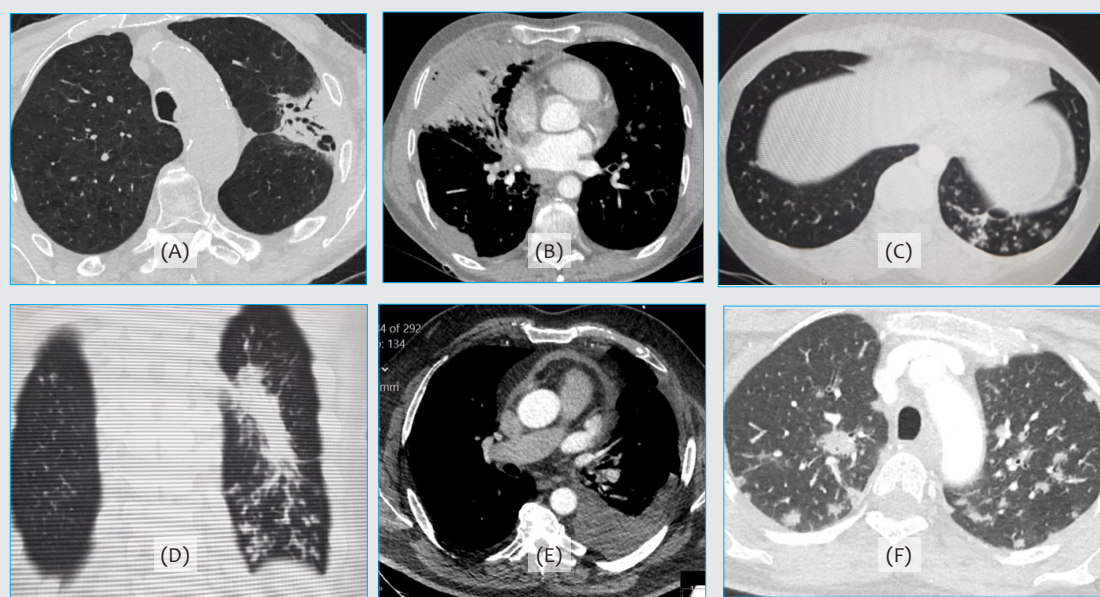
CT pictures of different patients represent example of non COVID-19. (A) and (B) show a consolidation lesions with obvious air bronchogram suggestive of lobar pneumonia. (C) and (D) show centrilobular nodules in the left lower lobe with tree in bud appearance suggestive of infectious bronchiolitis. (E) shows left pleural effusion and (F) shows multiple and bilateral nodules.
